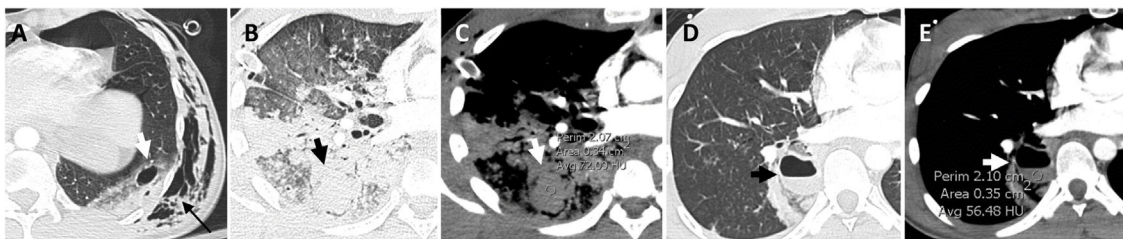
(A) 32-year-old male involved in a motorcycle accident. Axial chest CT image (lung window) showing a thin-walled pneumatocele (thick arrow) and subcutaneous emphysema (thin arrow). B and C) 39-year-old male involved in a motorcycle accident. Axial CT images of the chest (lung window [B] and mediastinal window [C]) showing a high-attenuation nodular lesion (72 HU) compatible with a haematocoele (arrow). D and E) 27-year-old woman who fell from the sixth floor. Axial chest CT images (lung window [D] and mediastinal window [E]) showing a cavitated nodular lesion with air-blood level (arrow) compatible with a pneumohaematocoele.
